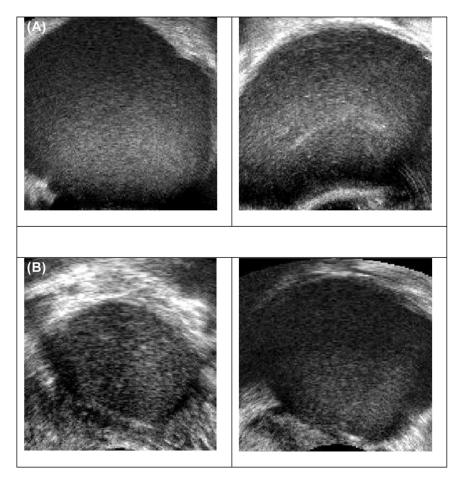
Sample ultrasound images of (A) benign ovarian tumor (upper panels) (B) malignant ovarian tumor (bottom panels).
